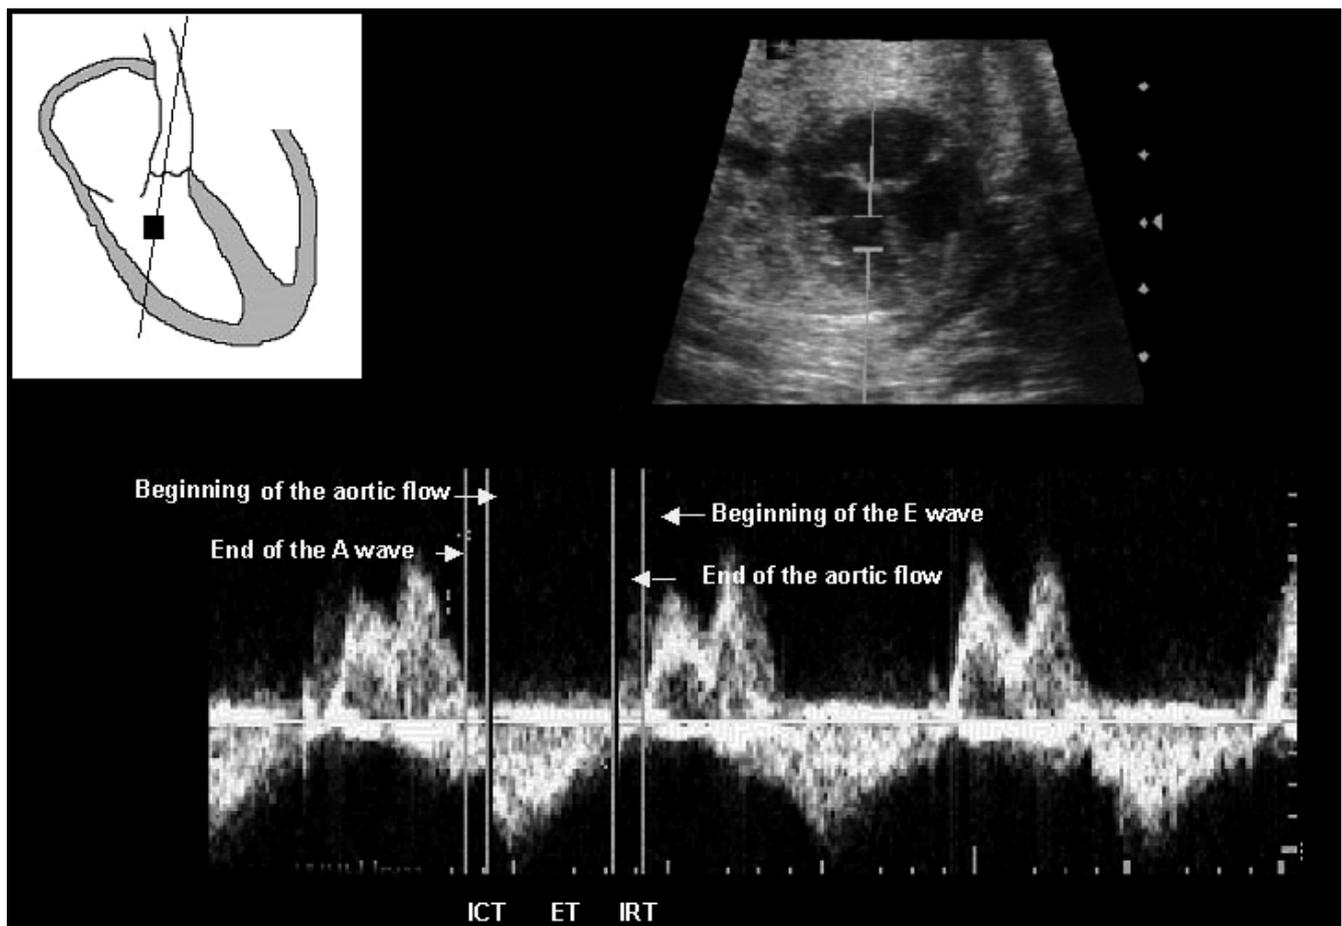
Doppler envelope of the myocardial performance index described by Friedman *et al.* (F-MPI)⁵. The sample volume is located in the left ventricle below the mitral valve. References for the time-period estimations were as follows: isovolumetric contraction time (ICT) from the end of the E/A waveform to the beginning of the aortic flow (AF), ejection time (ET) from the beginning to the end of the AF, and isovolumetric relaxation time (IRT), from the end of the AF to the beginning of the E/A waveform. The E/A waveform is always displayed as positive flow.
